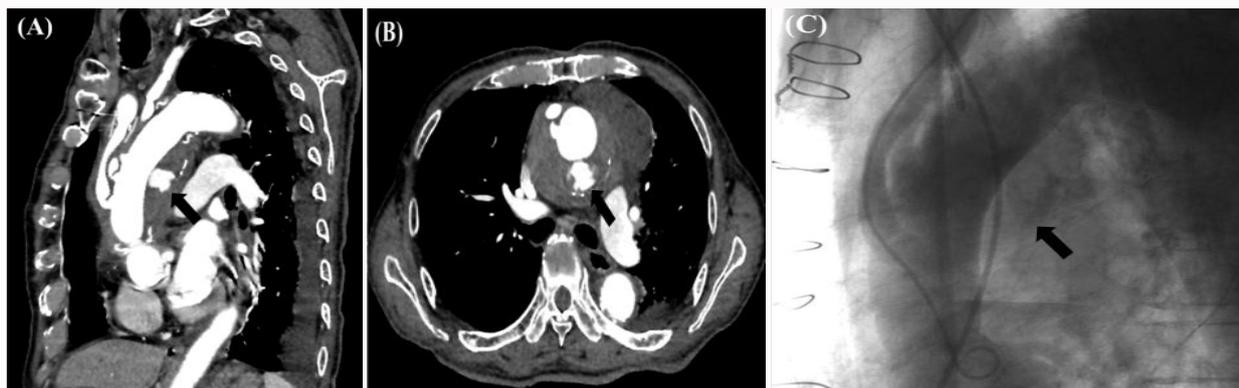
Computed tomography findings.
